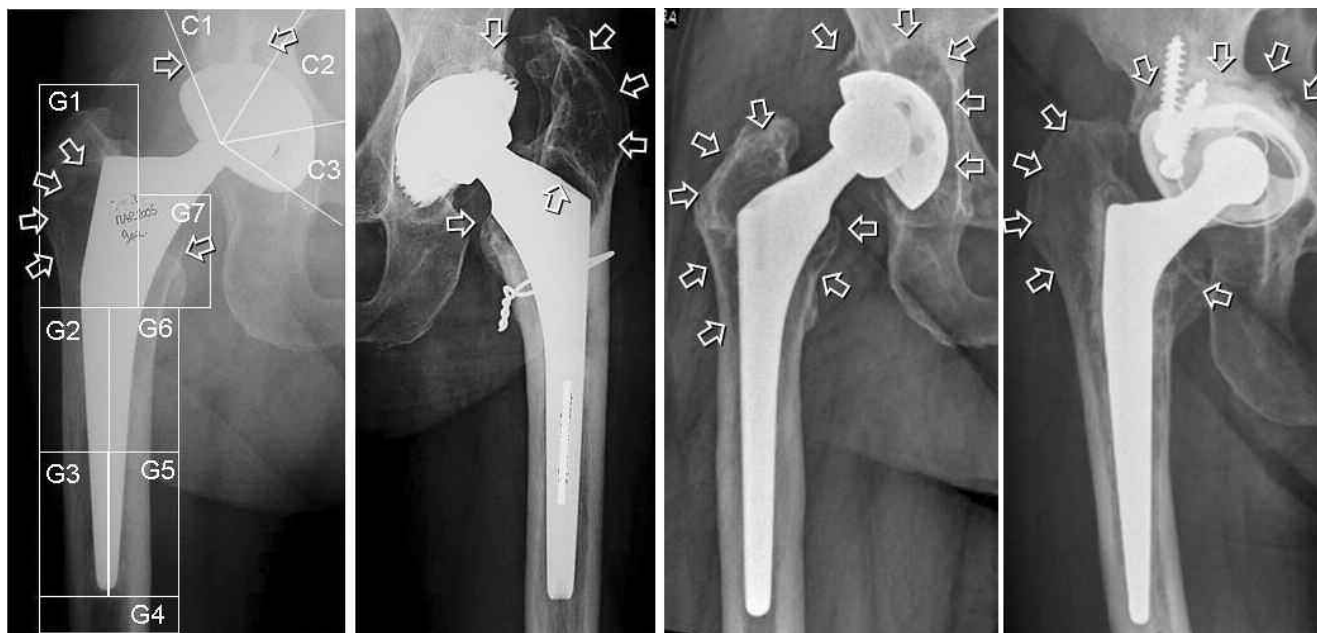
Patients radiographs showing sites of periprosthetic osteolysis (white arrows). In the first radiograph the Gruens Zones and Charnley Regions used for densitometric analysis of bone mineral density are shown.
